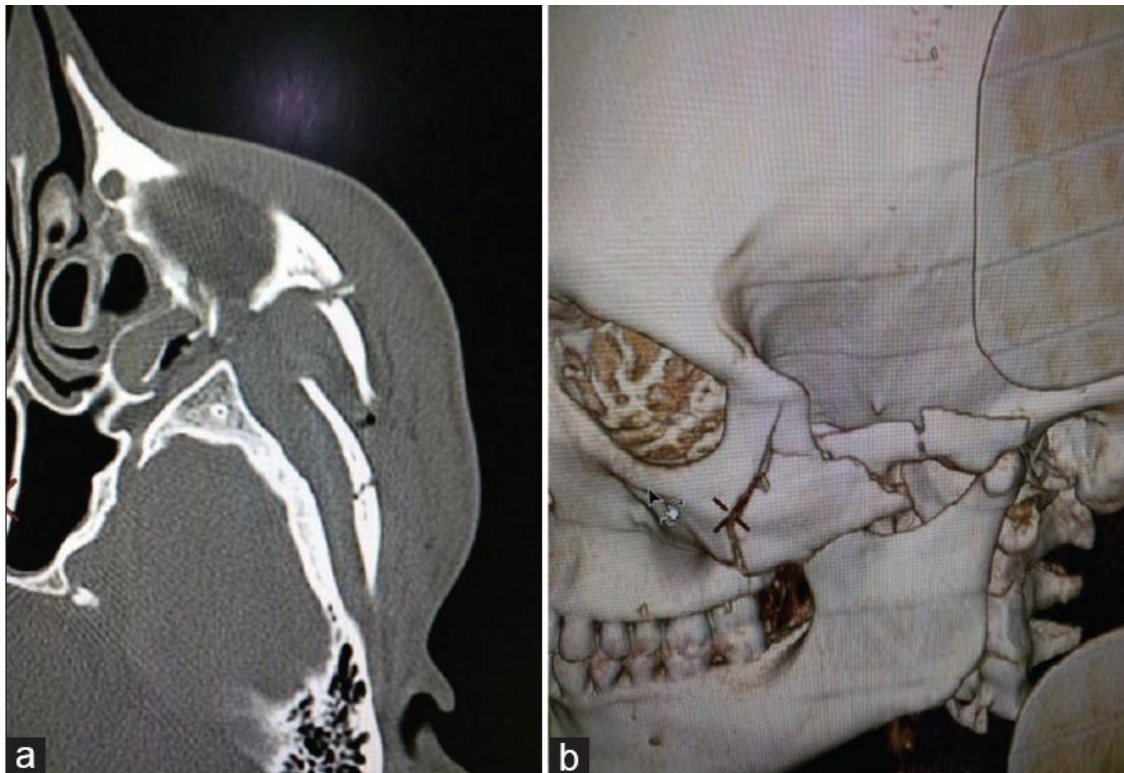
(a) Comminuted displaced fracture of the left zygomatic bone on axial CT. (b) 3D rendered images showing adequate information with enhanced visual perception of the extent of fracture and the displacement of the fracture fragments.
